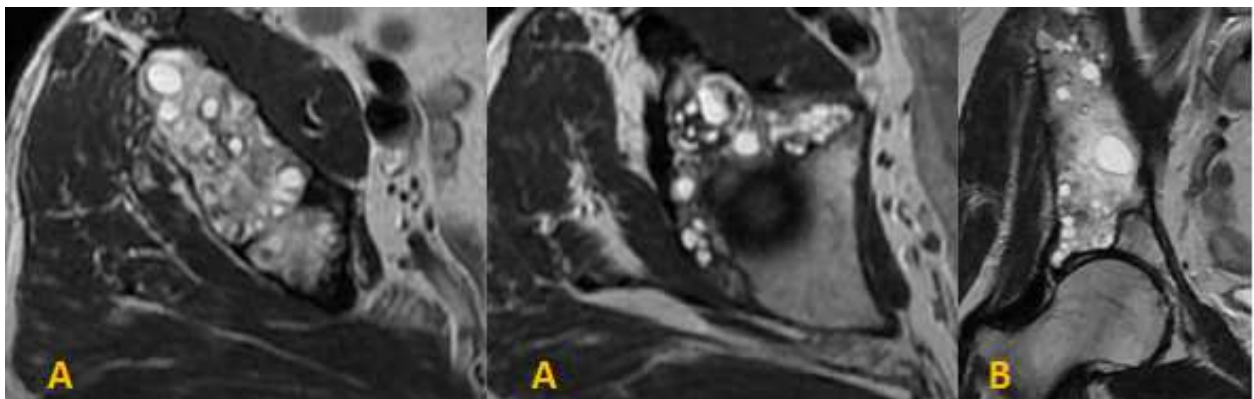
MRI imaging on T2 weighted ponderation (axial sections A and coronal section B), showing a multi locular cystic lesion of the right iliac bone.
